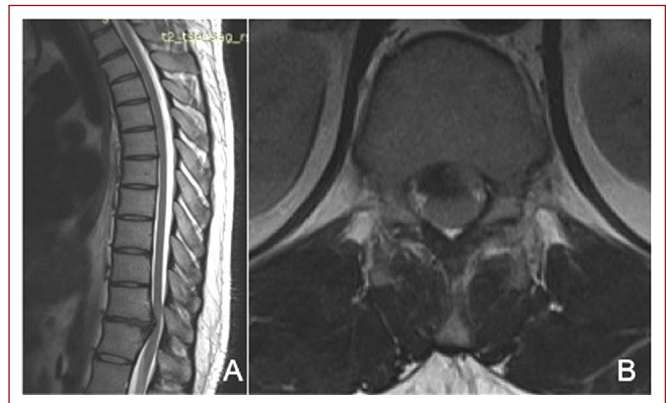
T2-weighted a) sagittal and b) axial MRI demonstrating central thoracic disc herniation compromising the spinal cord.
